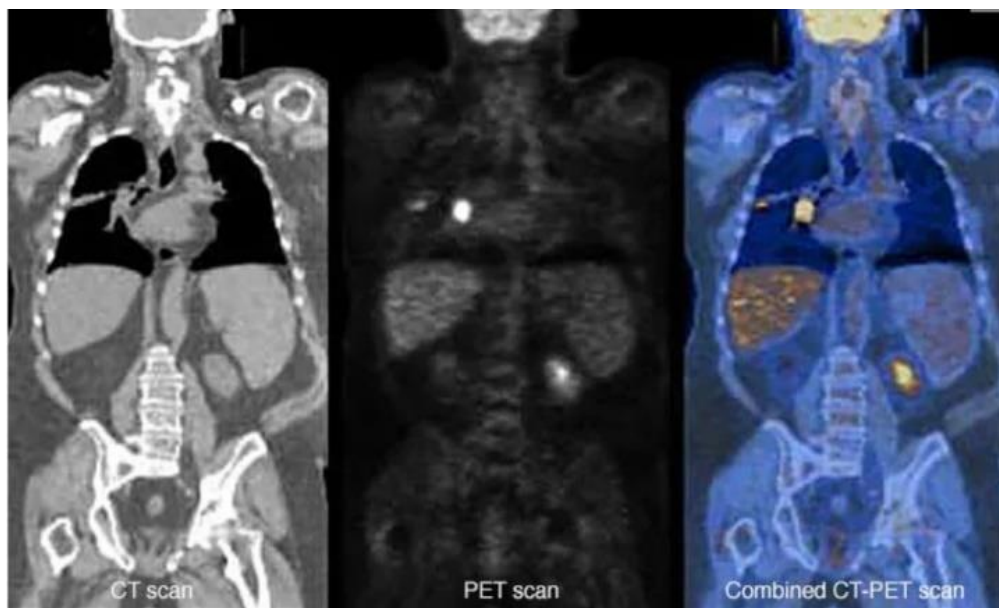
Combined PET-CT Devices (URL-5).
